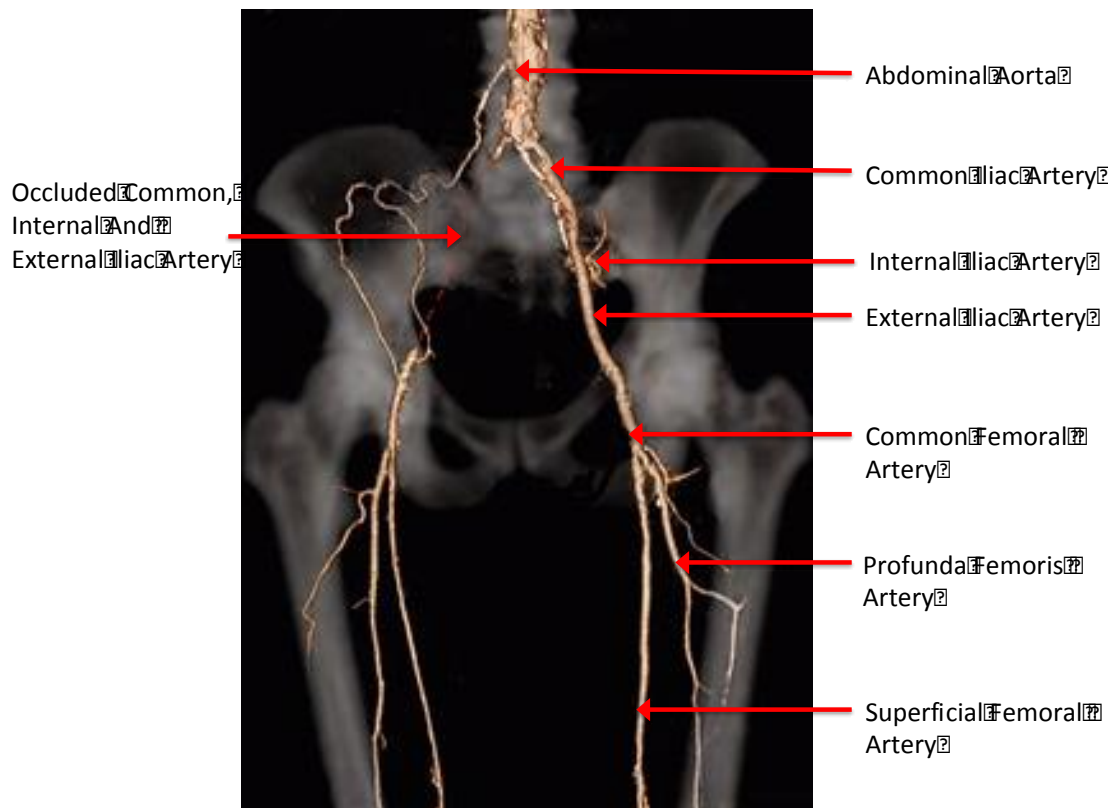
Computed Tomography Angiogram (CTA) reconstruction in a patient with PAD demonstrates occlusion of the right common iliac, internal iliac and external iliac arteries (red dotted line). This imaging can be used to plan revascularisation.
